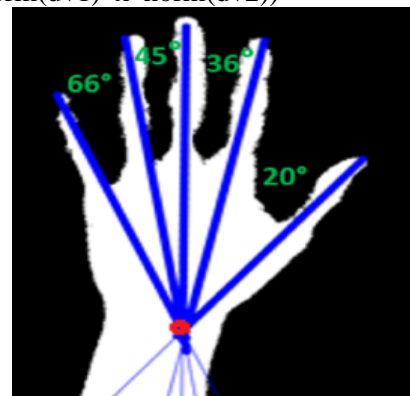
Normal angle computation of right-hand radiograph
